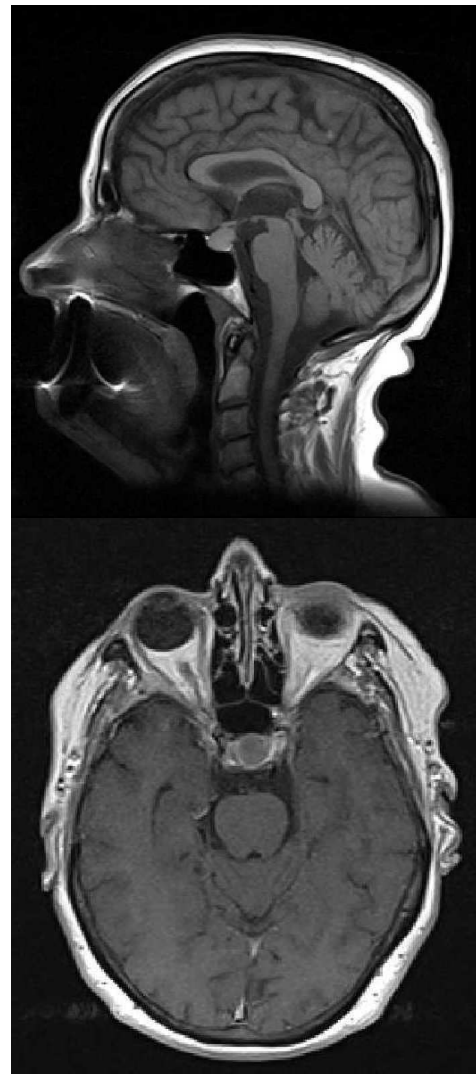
CT scan: tumoral mass located in the sellar region with suprasellar extension
